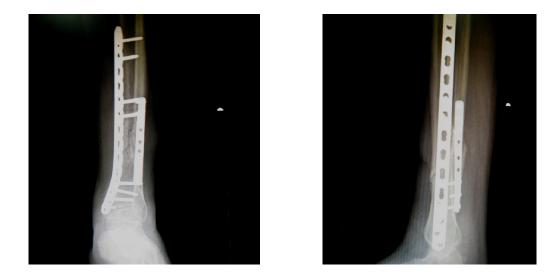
62. 16 Weeks post-operative X-ray
